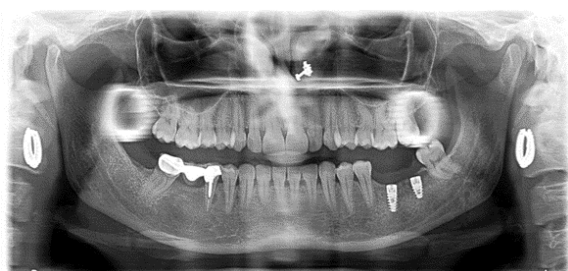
Immediate post-operative OPG X-Ray.
